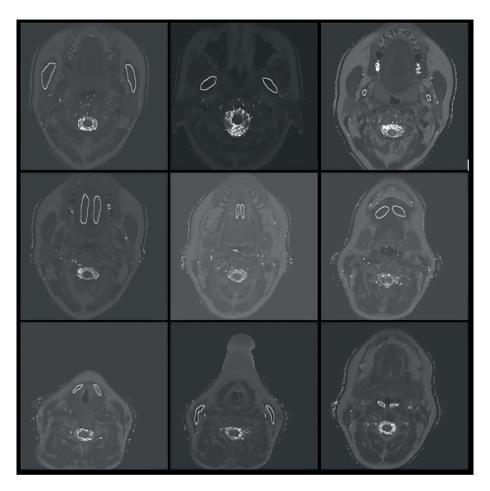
Examples of MRI slices with T2 measurements of (from top left to bottom right) the masseter, lateral pterygoid, medial pterygoid, intrinsic tongue, extrinsic tongue, suprahyoid, infrahyoid, sternocleidomastoid and superior pharyngeal constrictor muscles. White circles delineate the region of interests.
